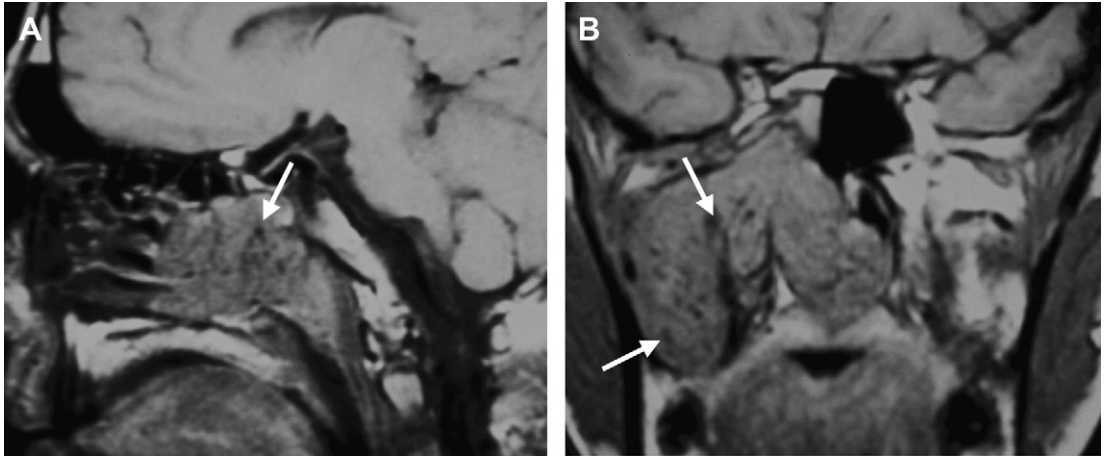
Axial (A) and coronal (B) T1-weighted MR images show a large lesion centered in the right pterygopalatine fossa, extending laterally into the masticator space through the pterygomaxillary fissure, medially into the posterior nasal cavity through the sphenopalatine foramen, and posteriorly and superiorly along the vidian canal and foramen rotundum. The lesion is slightly lobulated in contour but is well margined. Also, note the presence of serpentine flow voids (*white arrows*) reflecting its hypervascular nature (JNA).
